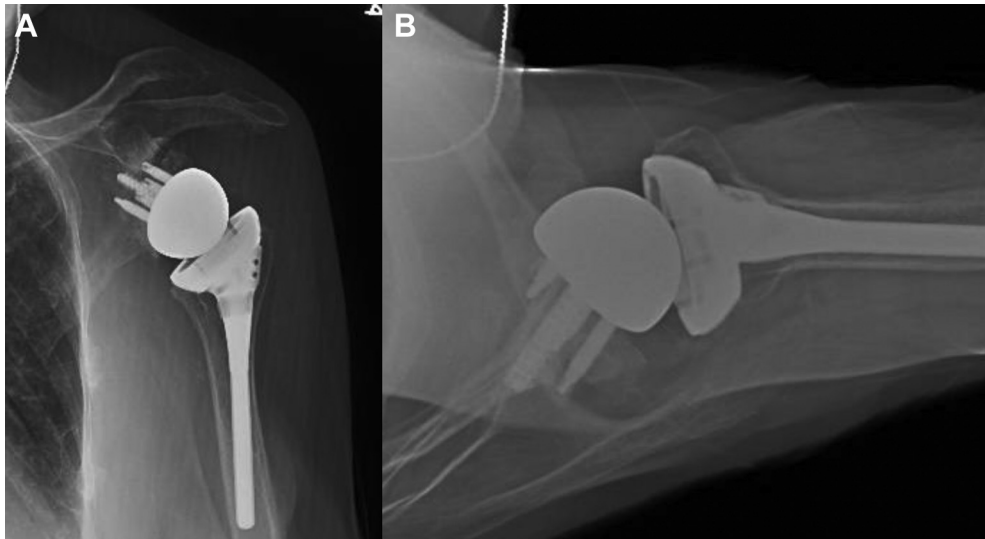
Postoperative radiographs showing alternative center-line placement of glenoid baseplate. (A) Anteroposterior radiograph showing placement with inferior tilt. (B) Axillary radiograph showing anteversion of baseplate and large posterior structural autograft.
